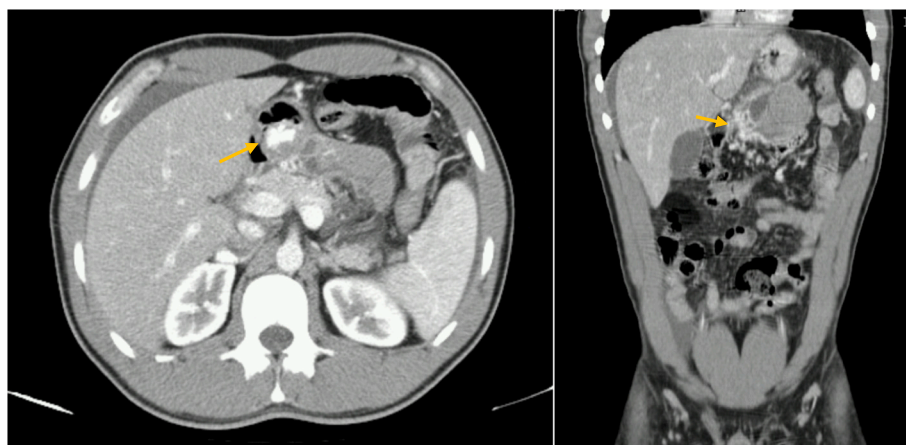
Computed tomography image on admission: hemoperitoneum with active bleeding (arrows) in the posterior wall of the duodenum/stomach.
